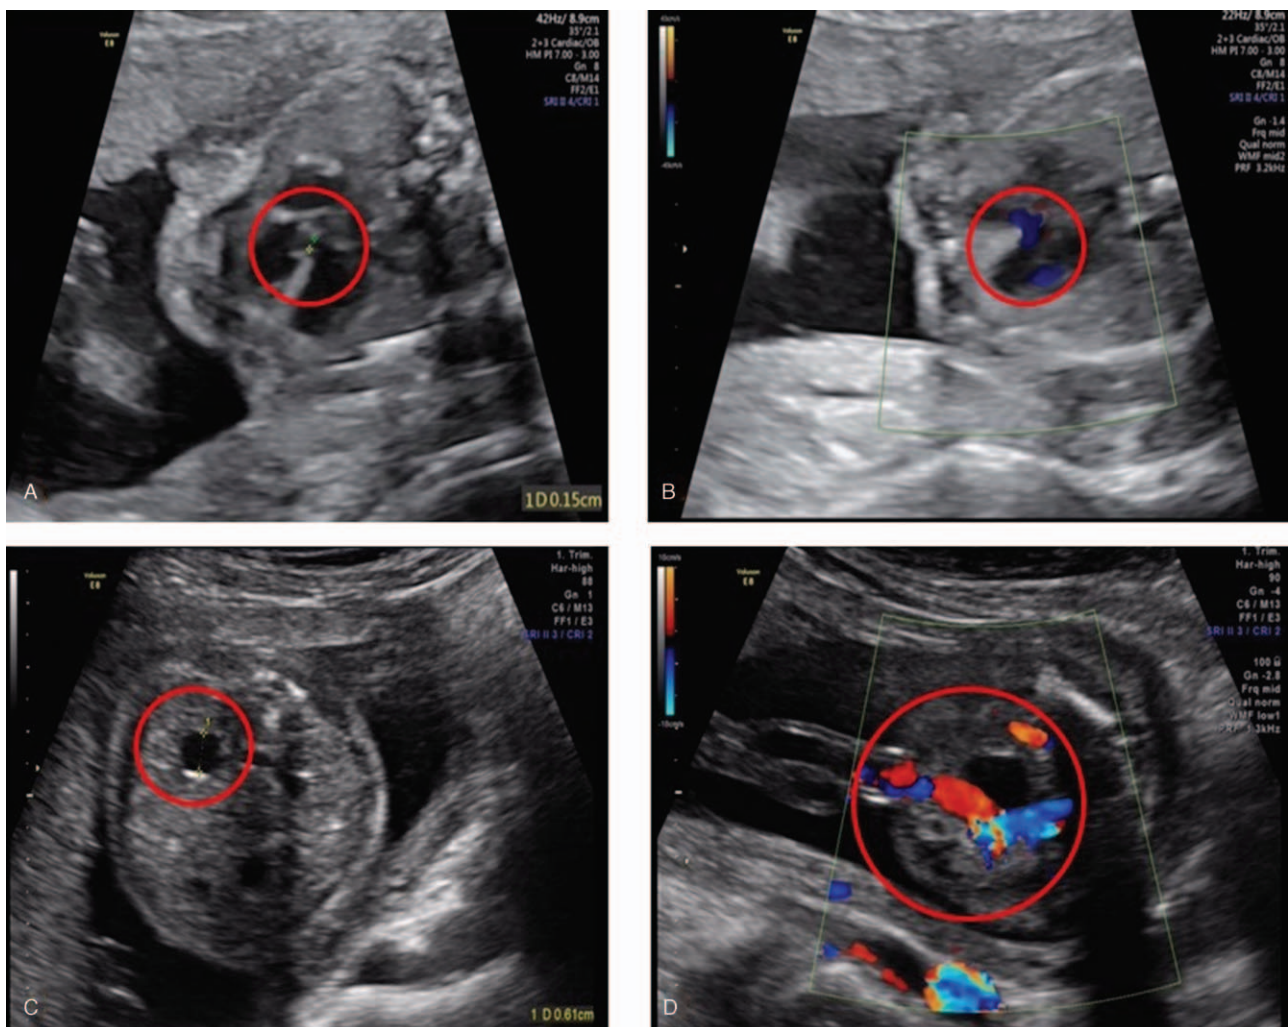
Prenatal ultrasound at 22 weeks of gestation showing: A: Interventricular septal defect; B: Presence of septal blood flow; C: Left renal pelvis widening; D: Single umbilical artery.
